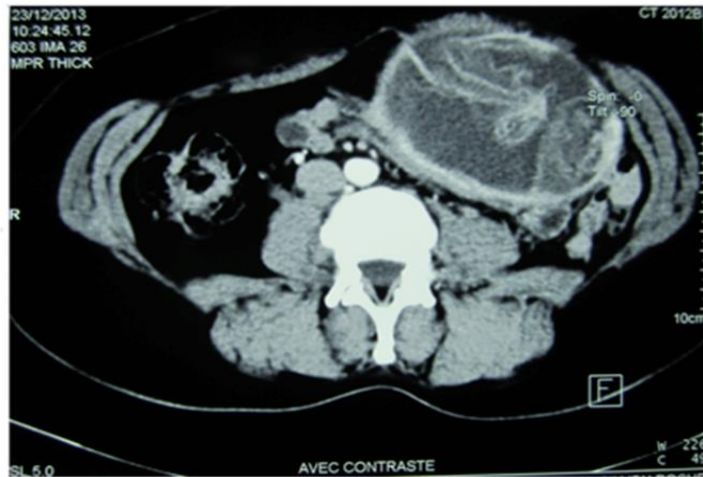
CT image showing a fluid mass of the left hypochondrium.
